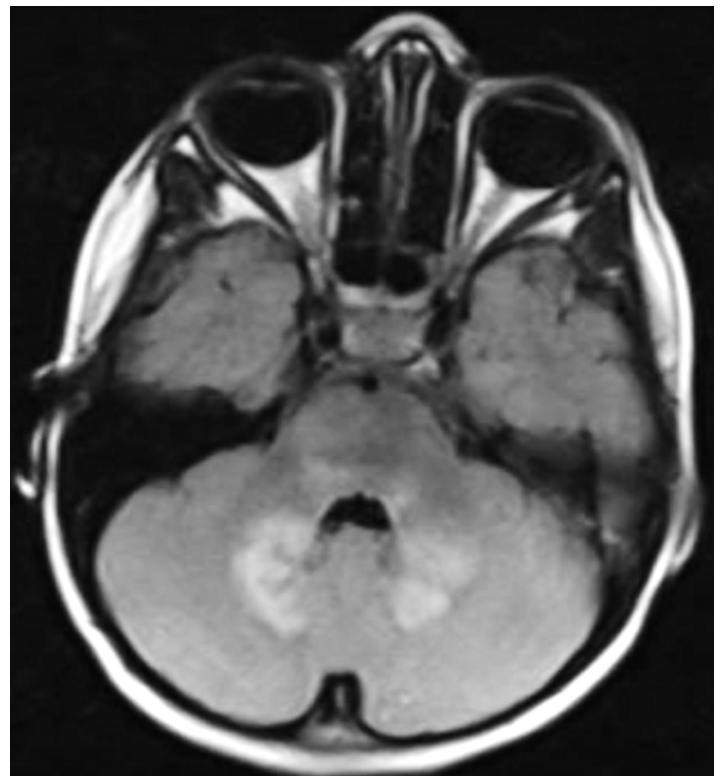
An 11-year-old male with NF1. Axial FLAIR weighted image show focal areas of abnormal signal intensity (FASI) in the cerebellum
